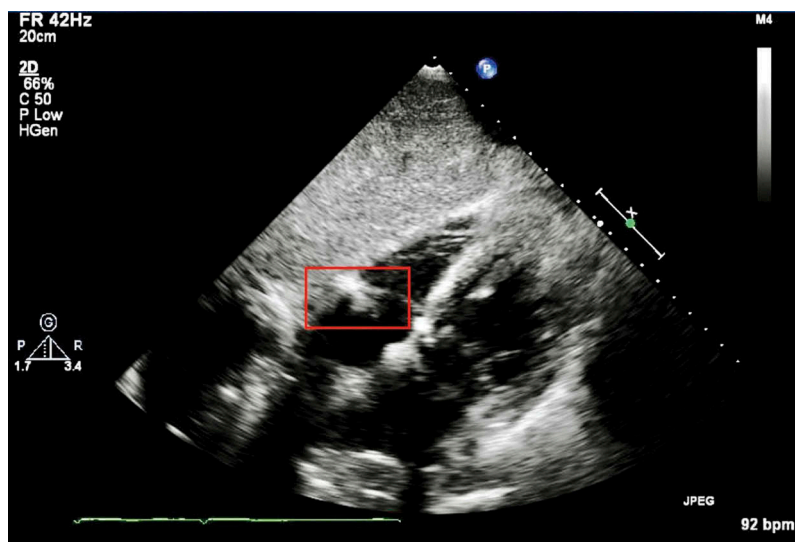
Echocardiogram.
